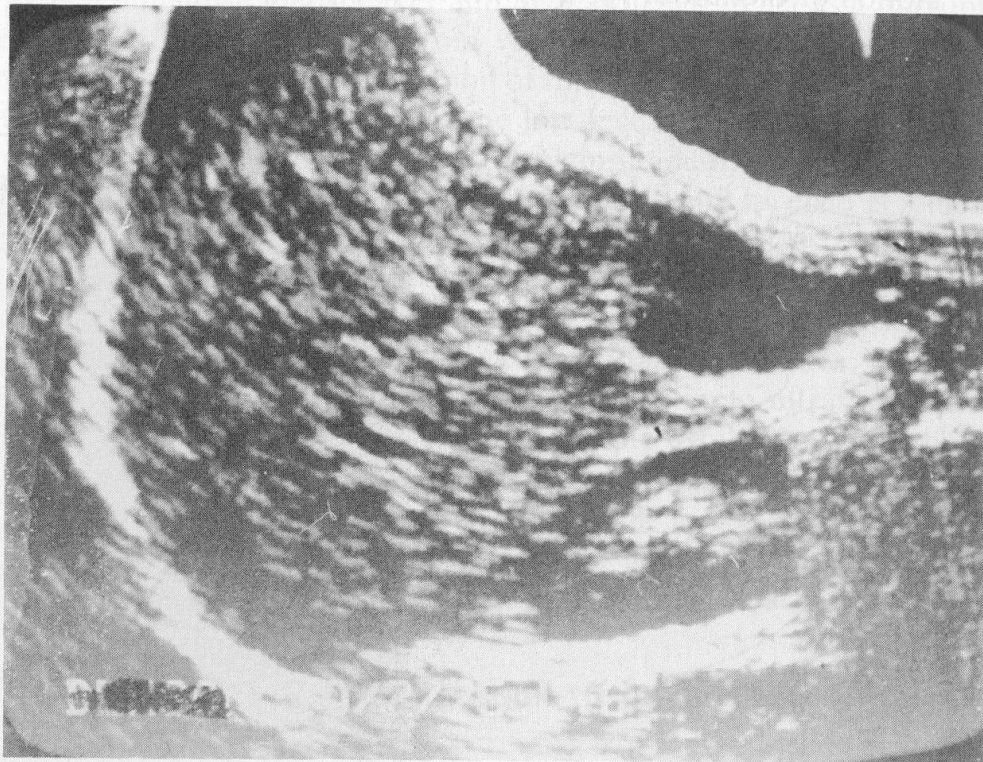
(a) B-mode ultrasonic imaging shows the two-dimensional shape and reflectivity of objects by using multiple-scan paths. (b) This B-mode ultrasonic image, which corresponds to (a), shows the skin of the belly at the top right, the liver at the left center, the gall bladder at the right above center, and the kidney at the right below center. The bright areas within the kidney are the collecting ducts.
